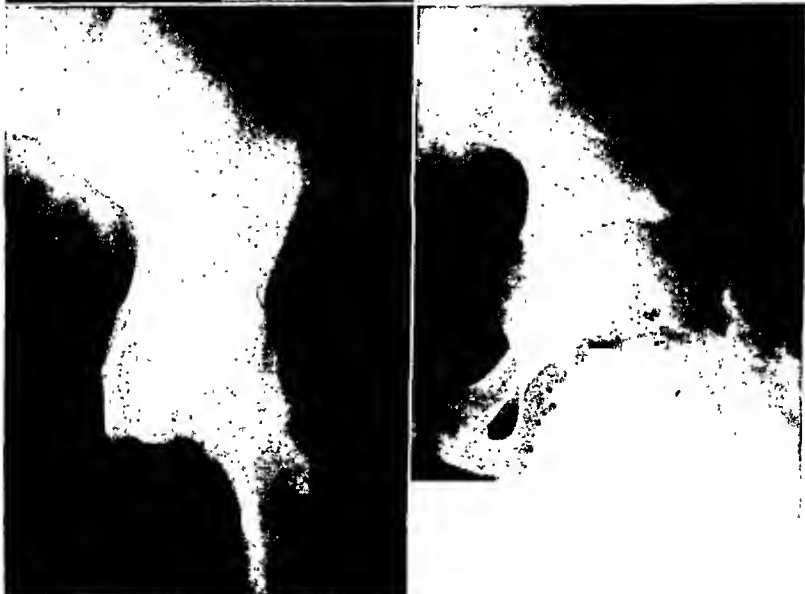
A, case A. C., preoperative x-rays, August 16, 1943; B, follow-up x-rays July 6, 1946.
